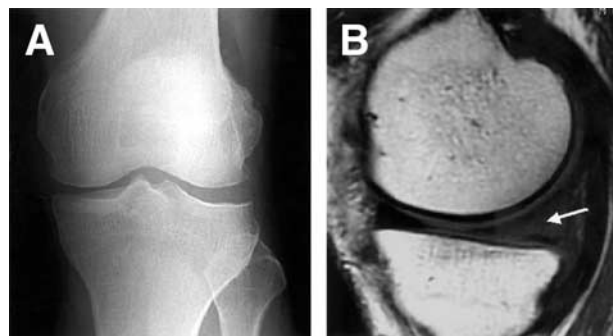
(A) Anteroposterior radiograph of the right knee made 1 month before meniscectomy. No abnormal finding in the MFC. (B) T1-weighted MRI made 2 weeks premeniscectomy shows a lesion with higher signal intensity in the posterior horn of the medial meniscus. Note that bone marrow in the MFC appeared normal.
